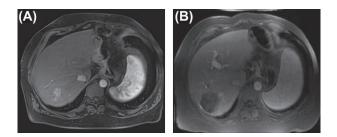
MR imaging of HCC. A: Pre-treatment. A solitary enhancing HCC is present in the right lobe. B: Post-transarterial chemoembolization. The HCC has been successfully treated, and there is an absence of viable tumor despite an increase in size of lesion.
